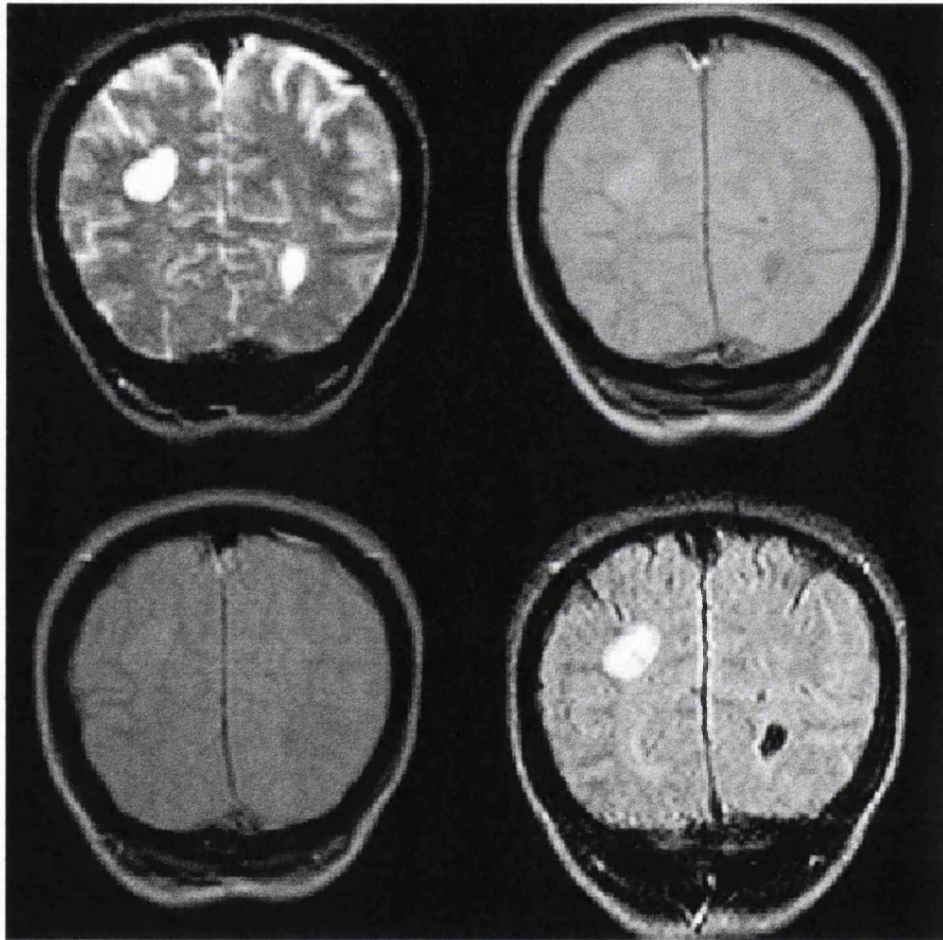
ADDITIONAL INFORMATION ON TUMOUR TEXTURE obtained with 3D fast FLAIR. Spin echo T2-image (top left), proton density weighted image (top right), T1-weighted image (bottom left) and 3D fast FLAIR image (bottom right). A lesion is shown in the right parietal lobe. Contrast is low on the proton density weighted image, T1- and T2-weighted images provide high contrast. However, both lesion and CSF (for example in the occipital horn of the left lateral ventricle) have similar signalintensities (low on T1- and high on T2-weighted images). FLAIR provides a high contrast for the lesion. The fact that the signal from the lesion is not suppressed on FLAIR indicates that the lesion is not a CSF filled cavity but a solid tumour. The patient had partial epilepsy.
